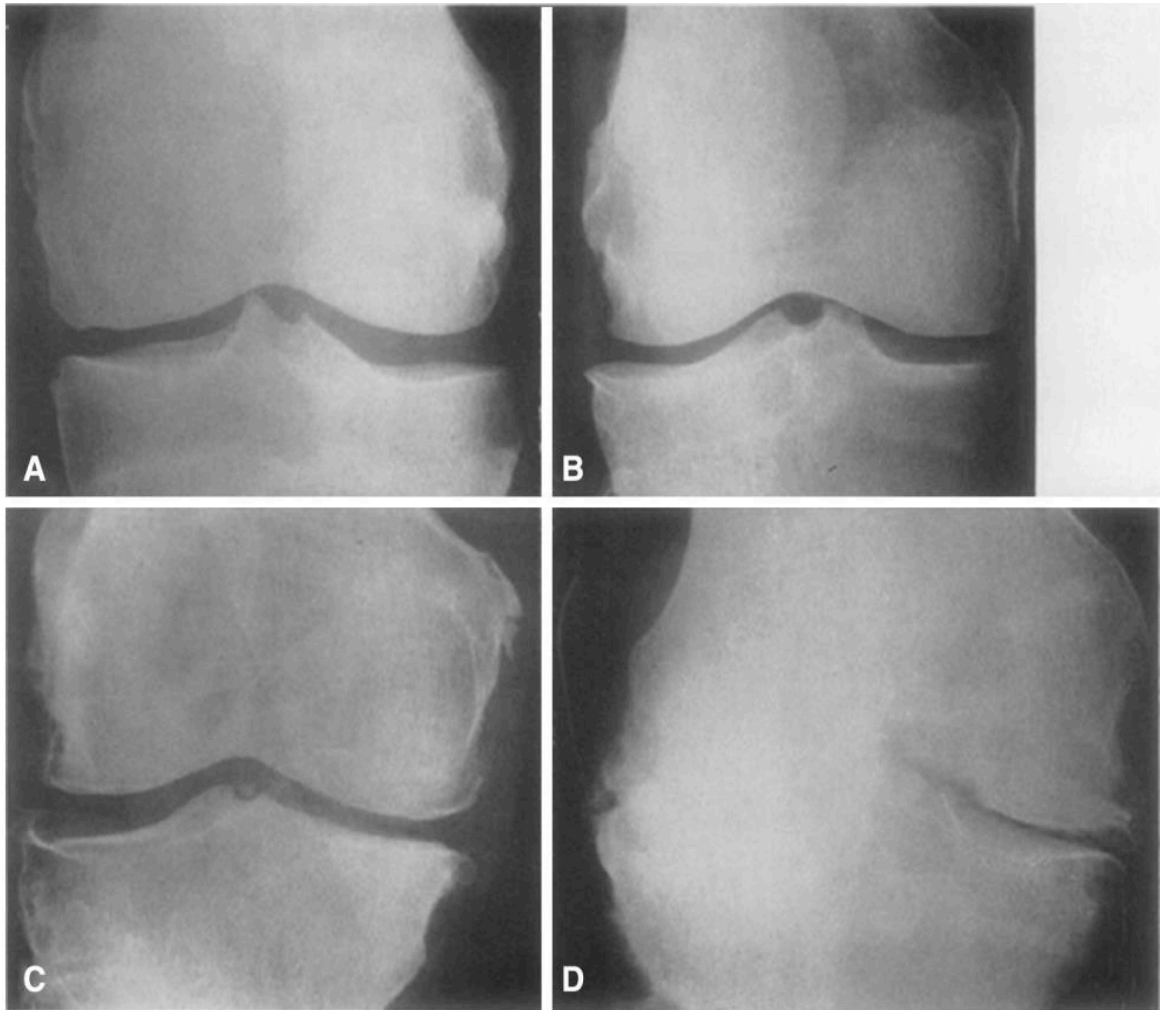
(A) Representative knee radiograph of KL classification Grade 1, which demonstrates doubtful narrowing of the joint space with possible osteophyte formation. (B) Representative knee radiograph of KL classification Grade 2, which demonstrates possible narrowing of the joint space with definite osteophyte formation. (C) Representative knee radiograph of KL classification Grade 3, which demonstrates definite narrowing of joint space, moderate osteophyte formation, some sclerosis, and possible deformity of bony ends. (D) Representative knee radiograph of KL classification Grade 4, which demonstrates large osteophyte formation, severe narrowing of the joint space with marked sclerosis, and definite deformity of bone ends (Adapted from Kellgren & Lawrence 1957)⁷⁶.
